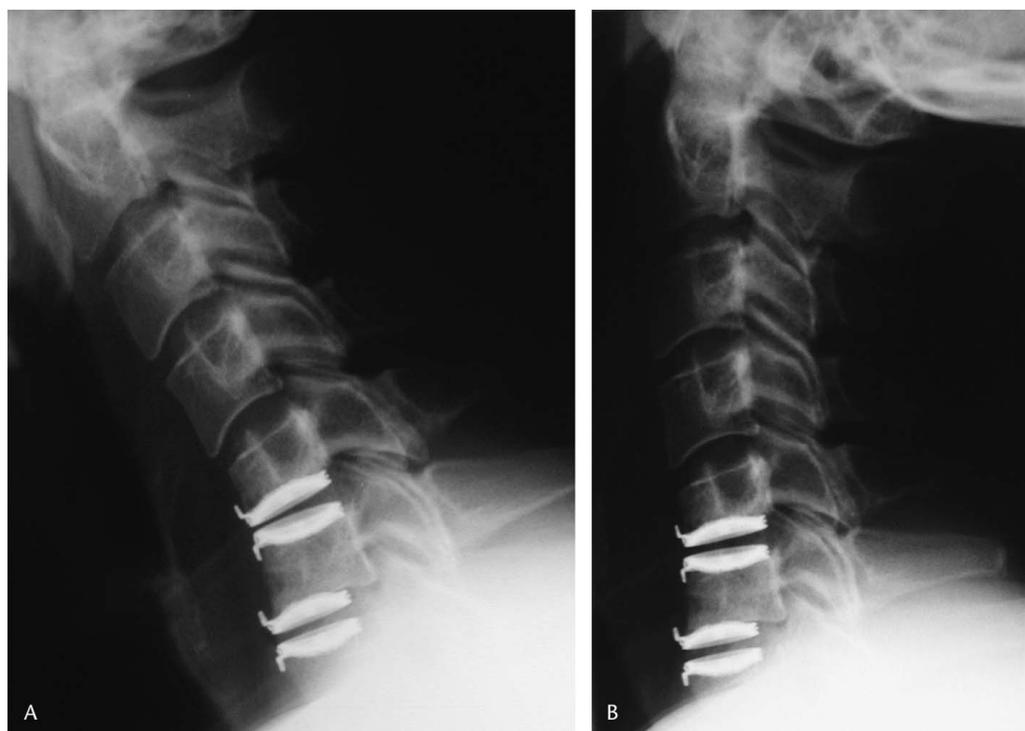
A and B, Immediate postoperative dynamic flexion/extension radiographs, confirming $>2^\circ$ of motion at C5–C6 with restoration of motion at this level.
